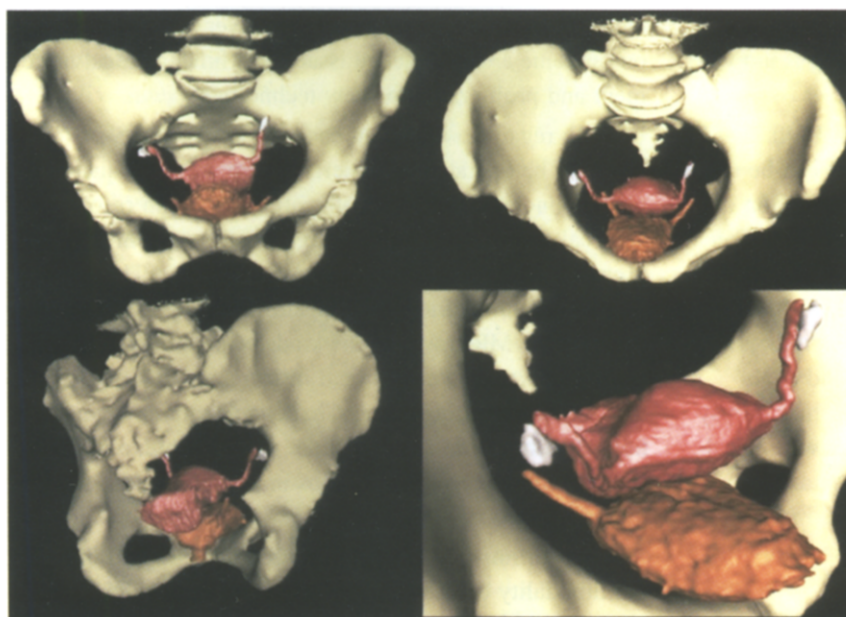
3D modeling from registered CT and MRI data.
